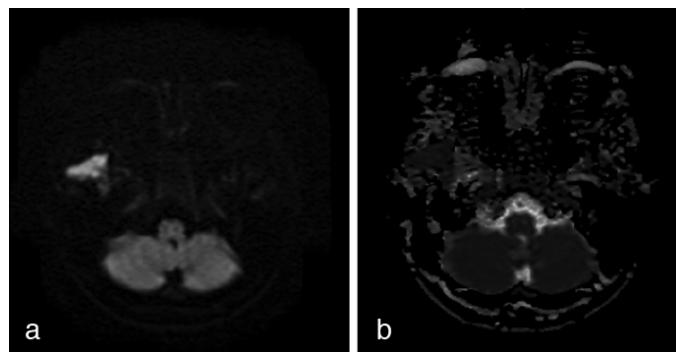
Follow-up: One year postoperatively, MRI revealed a patchy high-signal area in the DWI sequence (7a) and a patchy low-signal area in the ADC sequence (7b) from the right temporal region, indicating tumor recurrence.
